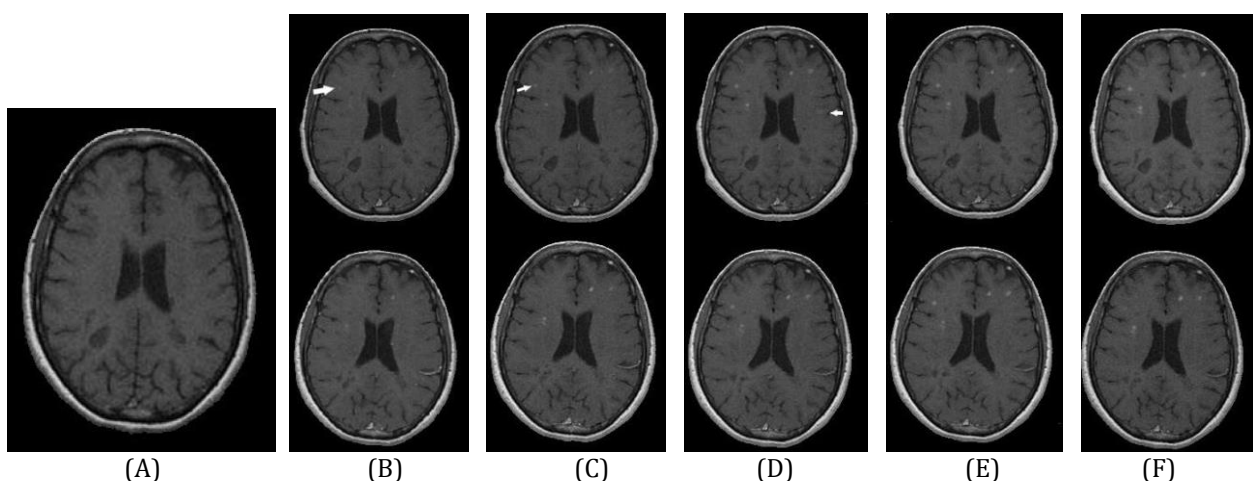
Axial T1-weighted MR imaging in a 35-year-old woman with an acute attack of MS. A T1W image without contrast. B-F, T1W images with contrast (upper row images are enhanced with Gadovist and lower row images are enhanced with Magnevist). Contrast-enhanced images show multiple demyelinating plaques in successive time sessions in both contrast agents (B, C, D, E, and F images are taken in 30 sec, 5 min, 10 min, 15 min, and 30 min after contrast injection, respectively). The images indicate that the number of small enhanced plaques has been relatively higher in Gadovist (arrows), compared to Magnevist. In addition, enhanced plaques are more prominent in later times.
